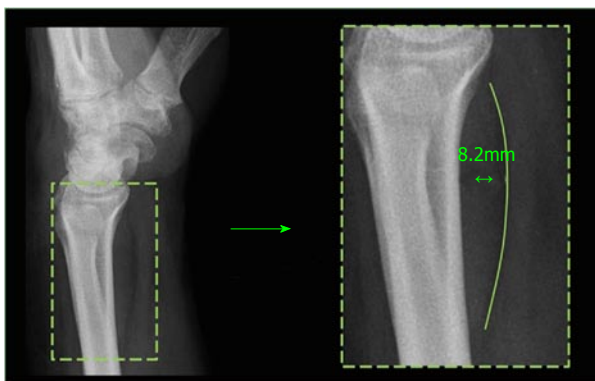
Measurement of the pronator quadratus complex on a lateral conventional radiograph.
